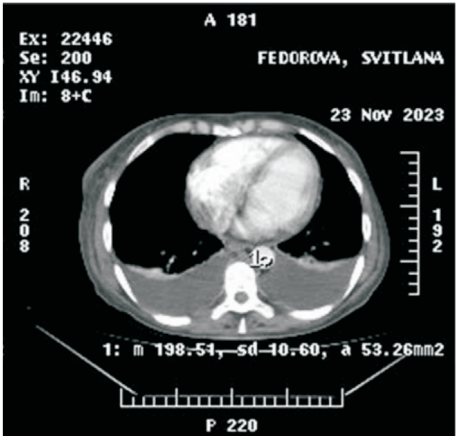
Hydrothorax shown on abdominal CT scan (sindx).
